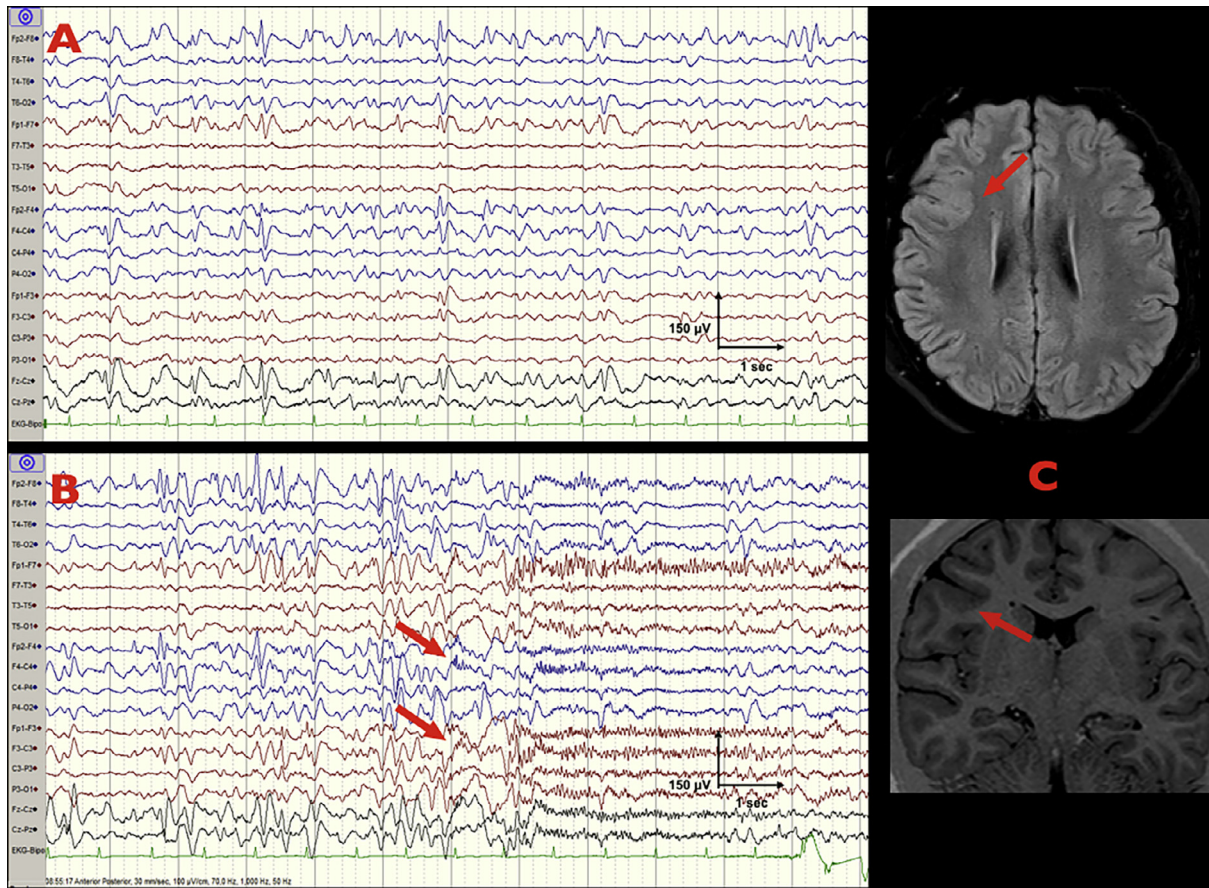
Reflex seizures in a patient with FCD in middle frontal gyrus. A: frequent interictal epileptiform discharges with a maximum over F4/Fp2/Fz electrodes. B: Ictal EEG during reflex startle seizure (onset is indicated by red arrows). Fast-spike discharges over the right lateral frontal region (Max F 4 electrode), and almost simultaneously involving contralateral homologous region and vertex, followed by low voltage fast activity which abruptly became generalized. C: FLAIR and T1-weighted MRI show focal cortical dysplasia in the right middle frontal gyrus.
